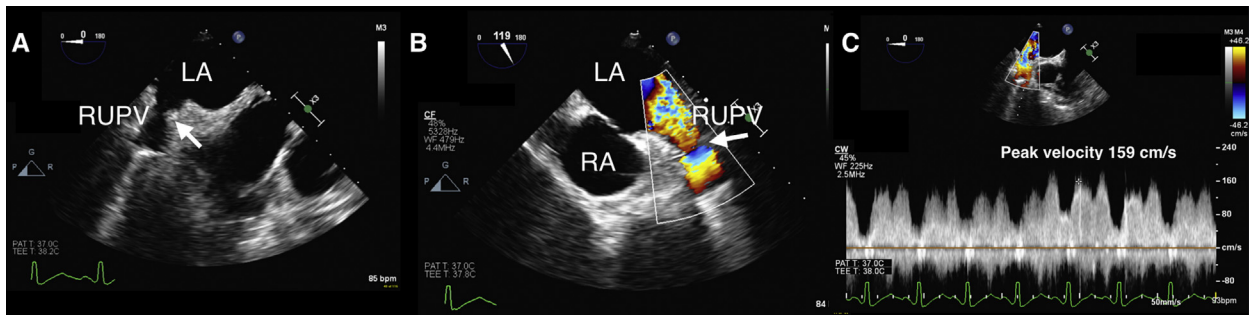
(A) ME right upper pulmonary vein (RUPV) view showing possible narrowing (*white arrow*). (B) Color flow Doppler interrogation of the RUPV shows flow acceleration (*white arrow*) at the level of narrowing. (C) Continuous-wave Doppler interrogation of the RUPV showing velocities of 159 cm/s. Evaluation of pulmonary vein velocities should be made within the clinical context. Abbreviations: LA, Left atrium; RA, right atrium.
